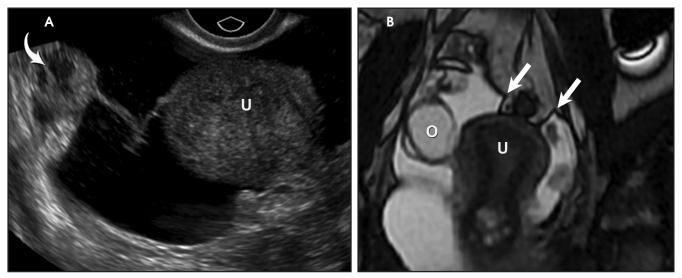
Peritoneal inclusion cyst. (A) A cystic pelvic mass with septations, which may mimic a cystic ovarian neoplasm, but the ovary was separate (curved arrow). Fluid occupies the entire pelvis, following the contour of adjacent organs (U = uterus). (B) Coronal T2 MRI image demonstrates the right ovary with a cyst (O), extra-ovarian free fluid that does not have an oval appearance but acute angles (arrows) following the shape of adjacent organs (O-RADS 2).
